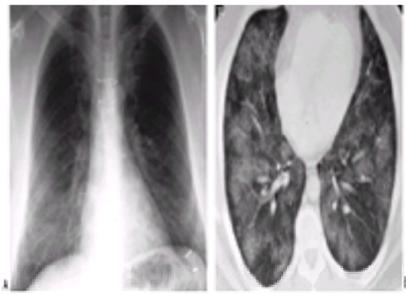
A: Pulmonary alveolar proteinosis. PA chest radiograph demonstrates bilateral, predominantly basilar infiltrates in a 50-year-old man with progressive exertional dyspnea. B: CT in the same patient demonstrates multiple foci of ground-glass opacification throughout through parenchyma. Open lung biopsy demonstrates classic features of PAP.
